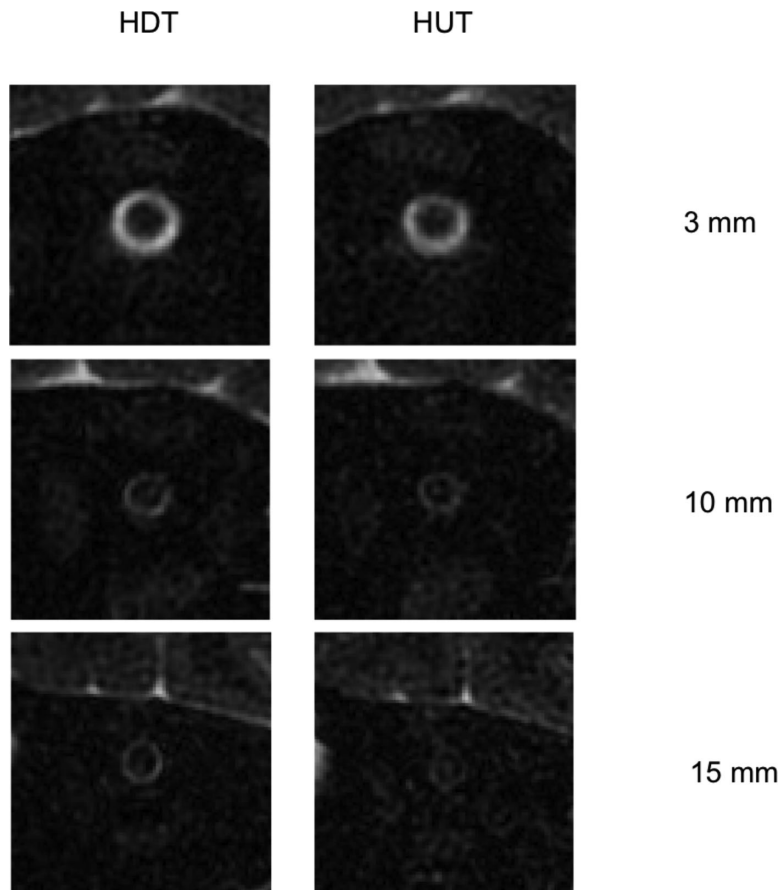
MRI of the ONSAS in a test subject in HDT and HUT 3, 10, and 15 mm behind LC. The ONSAS is annulus-shaped and visible in all images.
